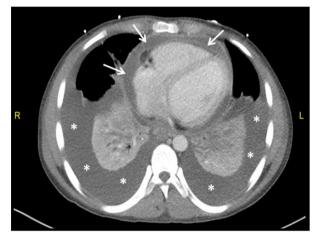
High-resolution computerized tomography (HRCT) showing bilateral pleural effusions (asterisks) and pericardial effusion (arrows).
